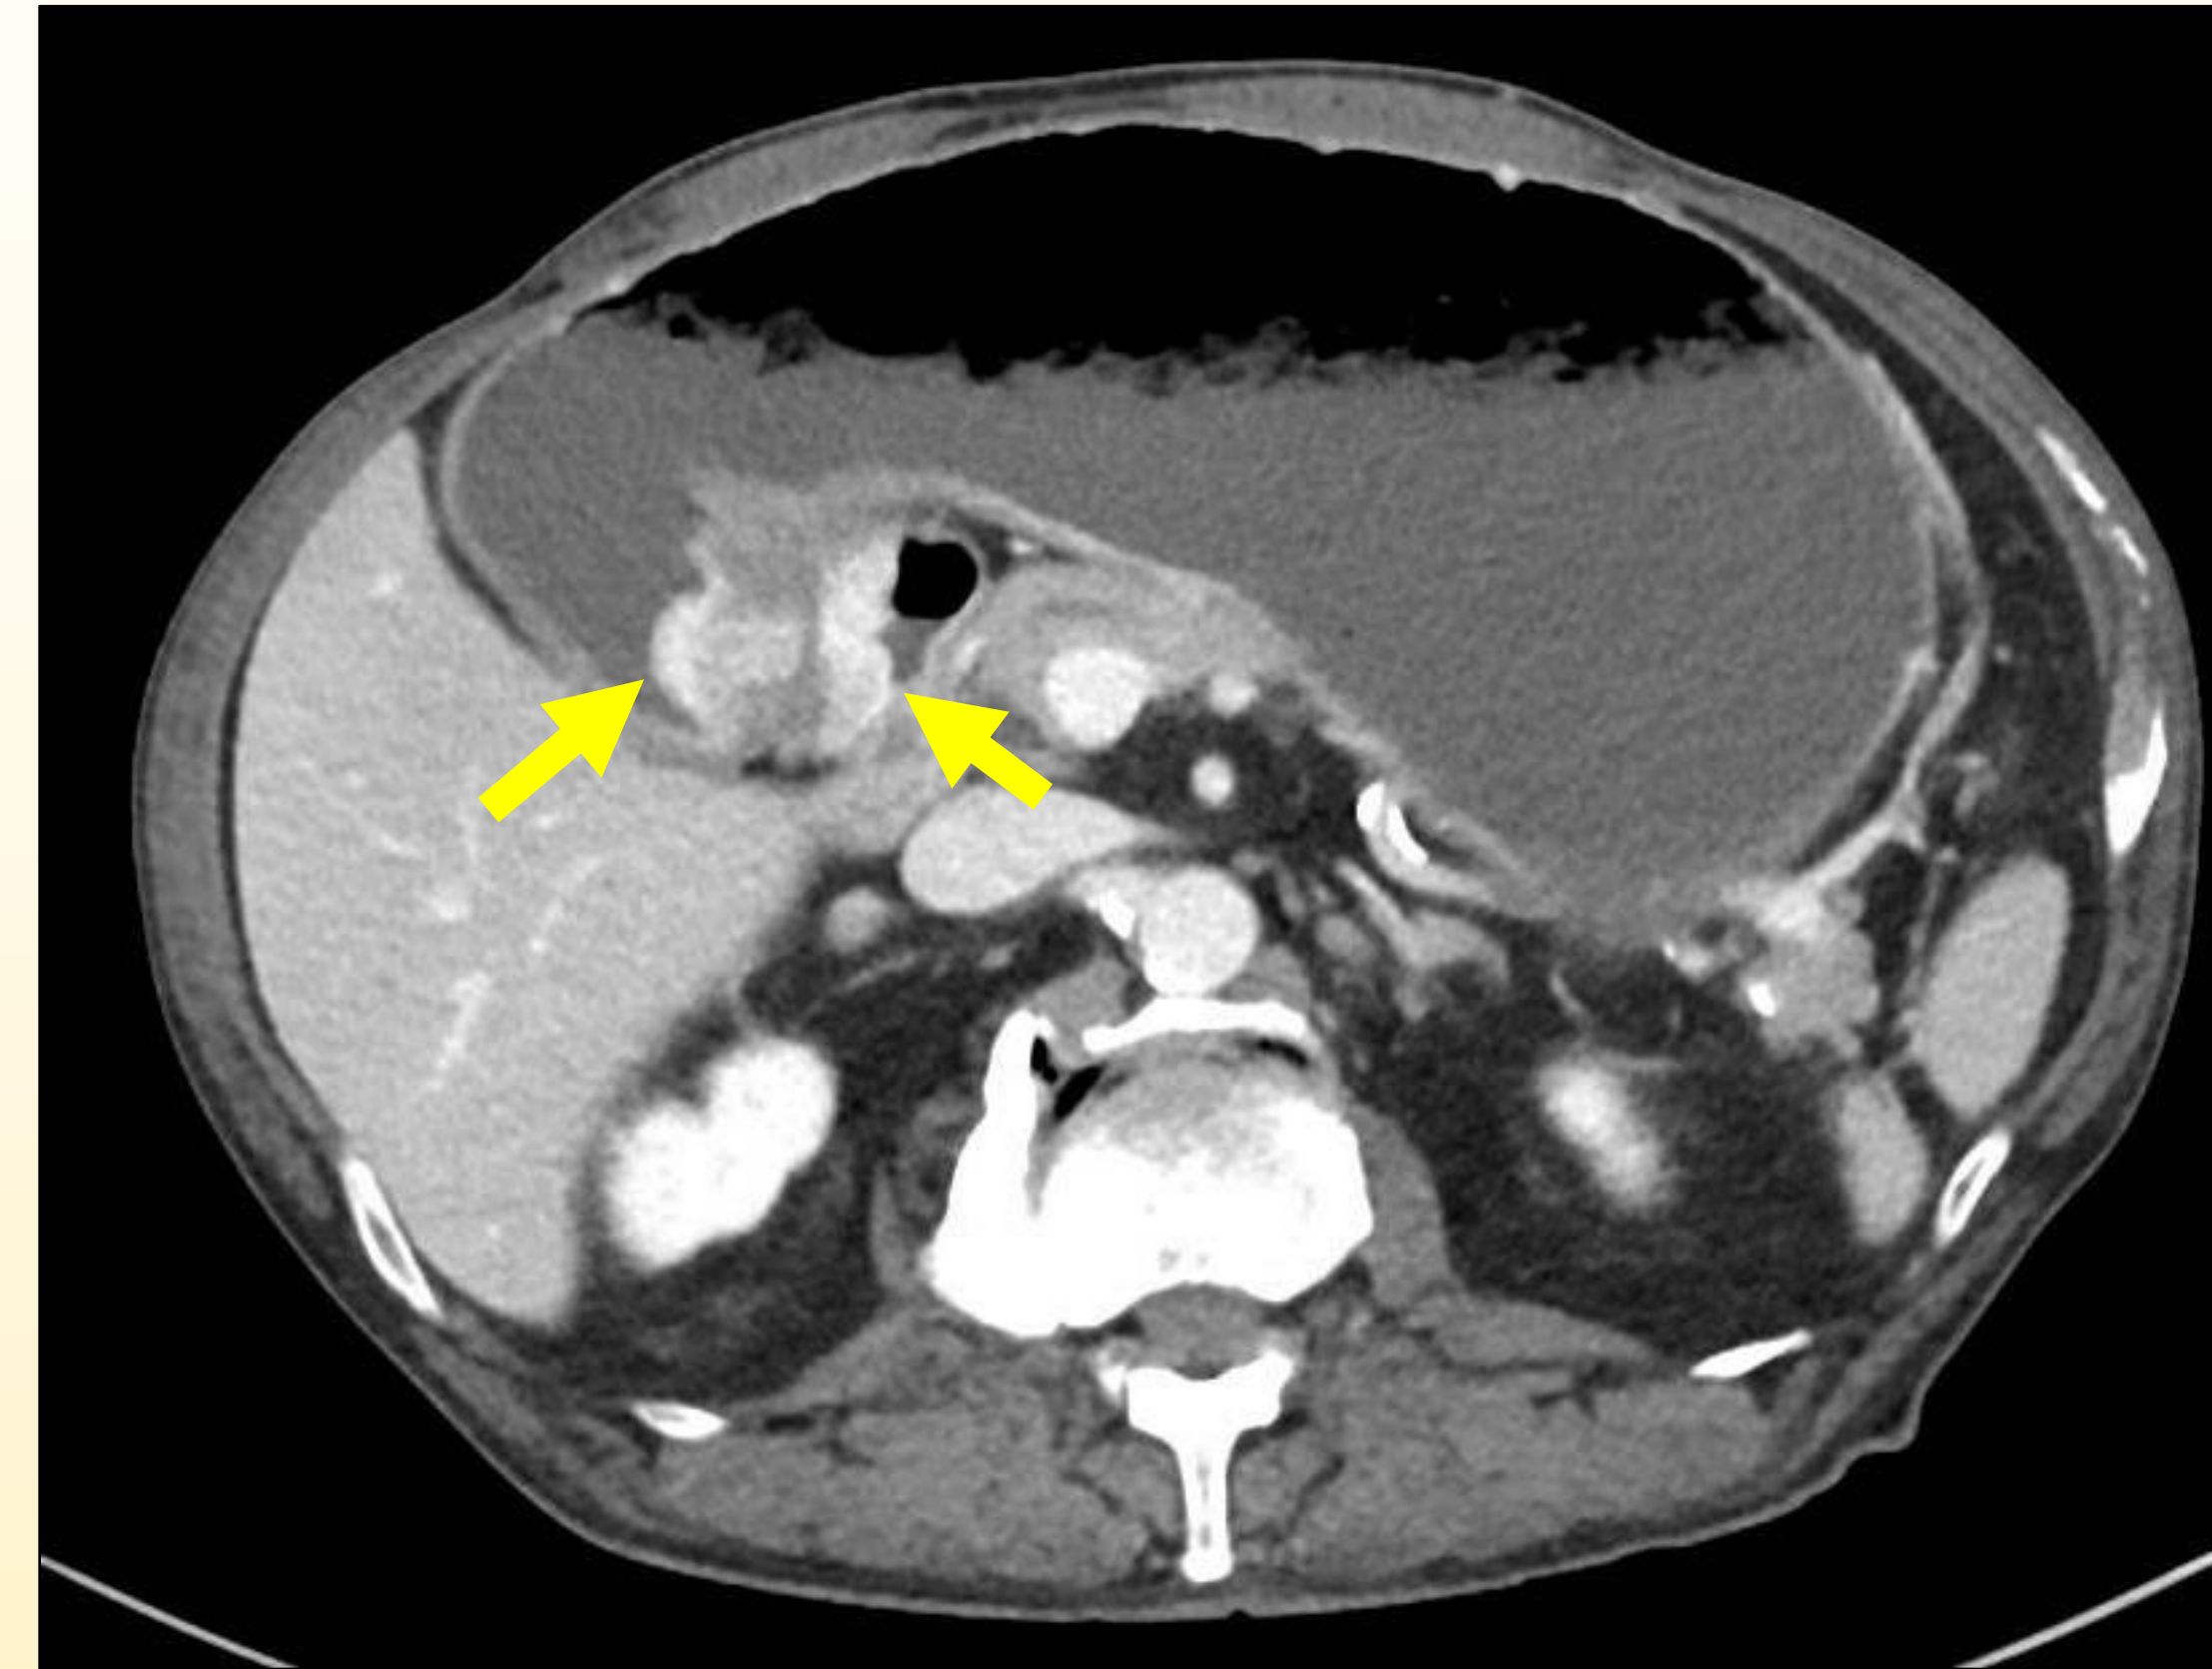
Abdominal CT axial section showing circumferential nodular wall thickening of the pylorus (yellow arrows) and distended, fluid-filled stomach.
